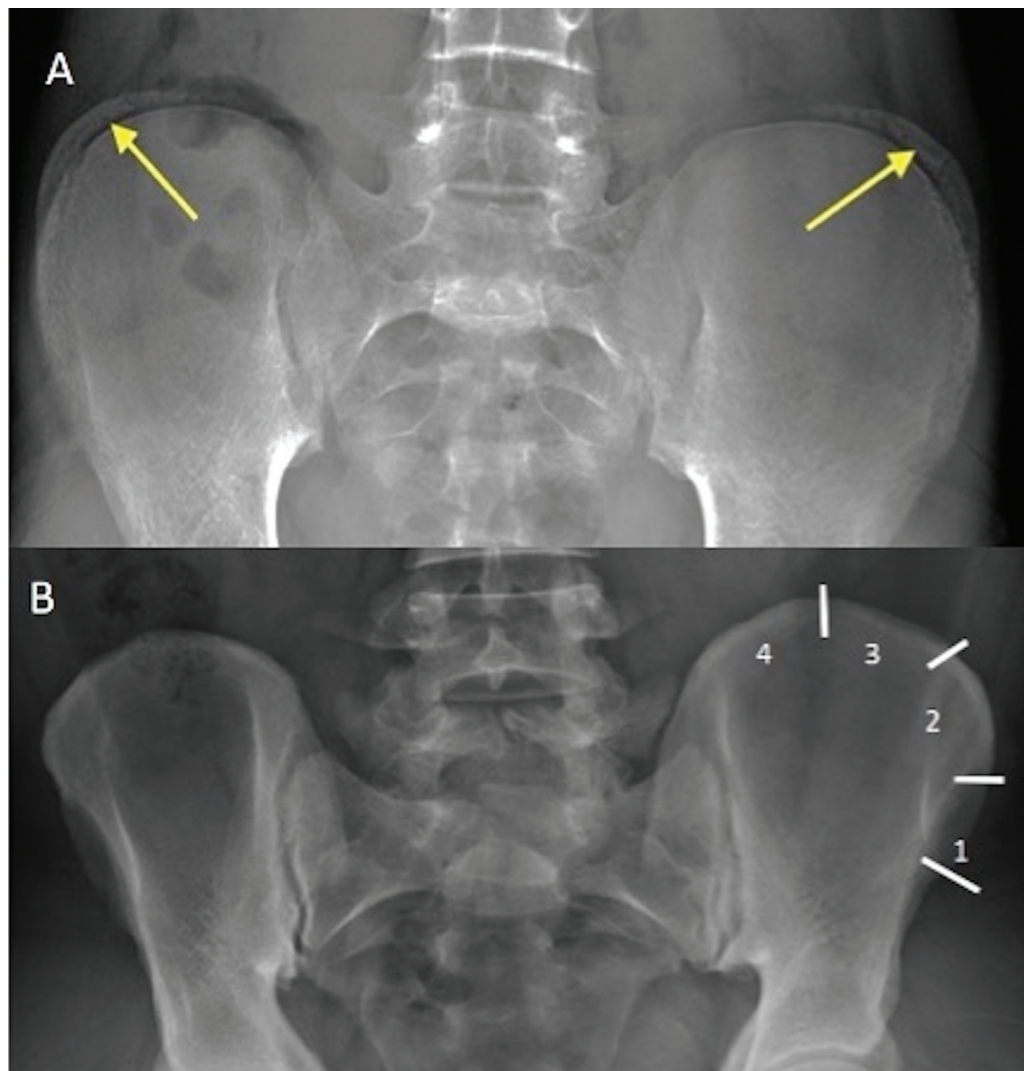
Anteroposterior radiograph of pelvic bones of a 15-year-old girl showing (A) unfused bilateral crest of ilium (yellow arrows), with 75% ossification (Risser grade 3). (B) Completely fused bilateral iliac crests (Risser grade 5) of a 17-year-old girl. Numbers indicate Risser grade based on ossification of iliac crest.
